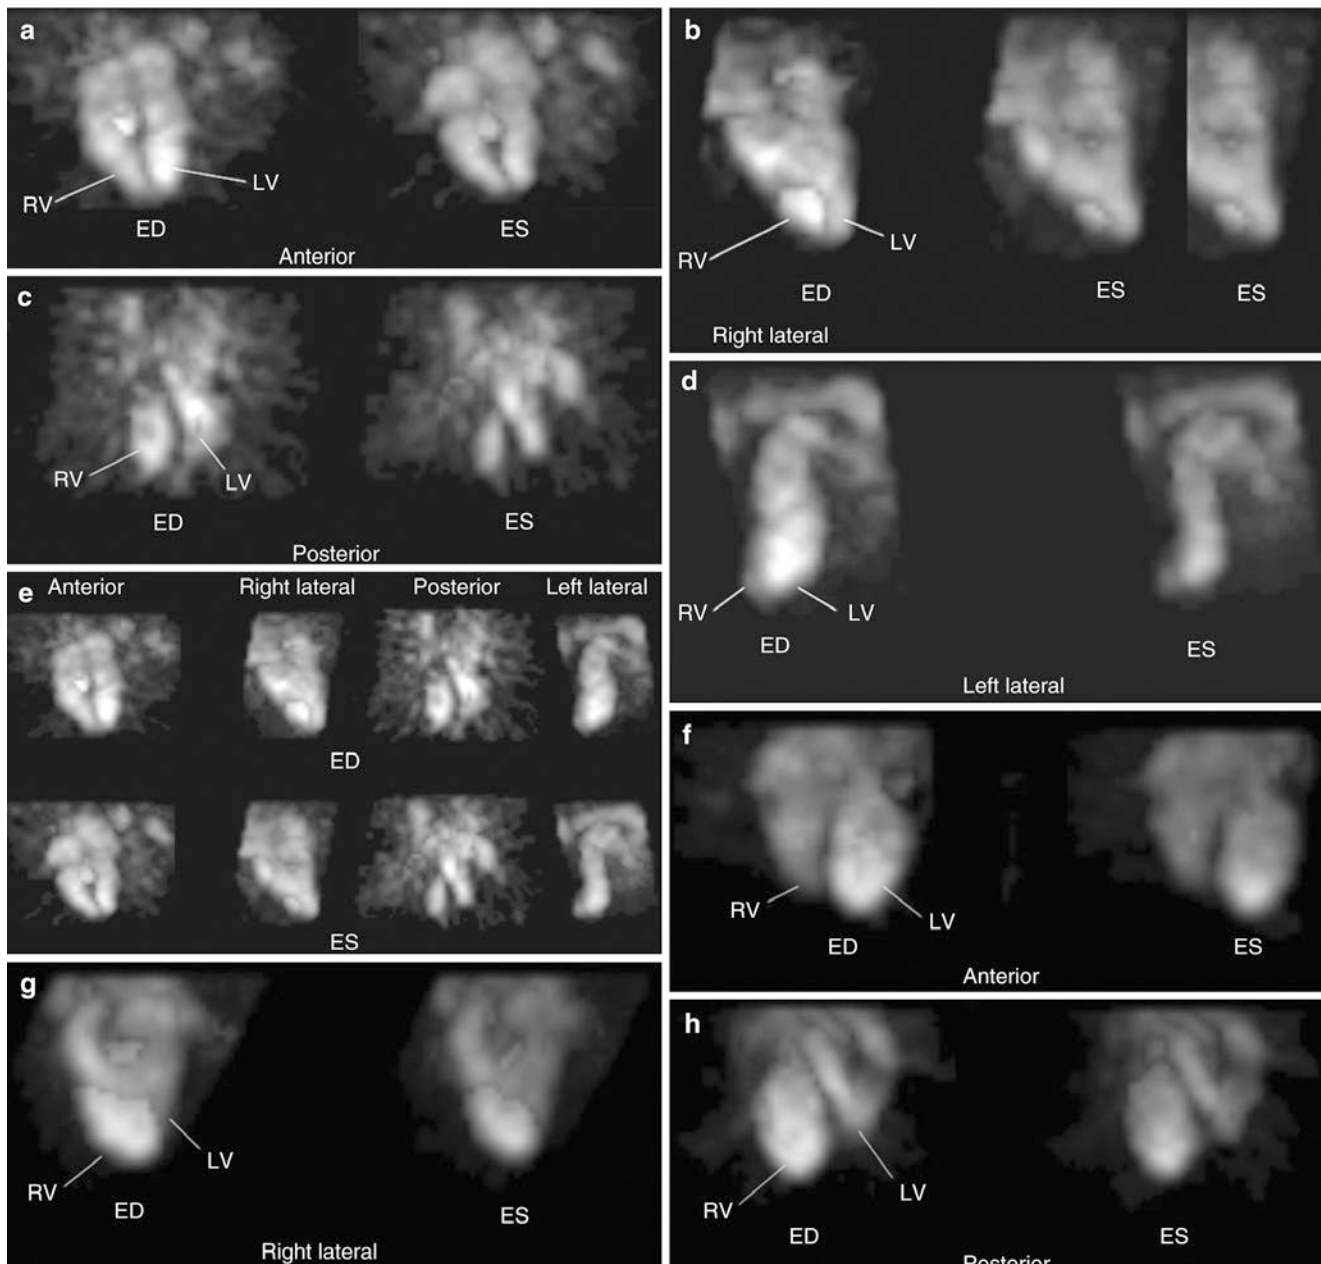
SPECT blood pool imaging. This three-dimensional (3-D) reconstruction of SPECT gated equilibrium images of a normal ventricle in end diastole (ED) and end systole (ES) viewed from multiple angles counterclockwise around a 360° orbit, from anterior (a) to right lateral (b) to posterior (c) and left lateral (d) views. (e) ED and ES images in all views of this normal heart are shown in a single panel. (f–i) the same views as in (a–d) This 3-D reconstruction of ED and ES gated blood pool images (using the same views as a–d) shows a patient with an anterior, apical, and septal LV aneurysm. The arrow in (i) points to the dynamic base of the LV, where the distal aspects are essentially akinetic. This is not well appreciated in other views. (j) The ED and ES
